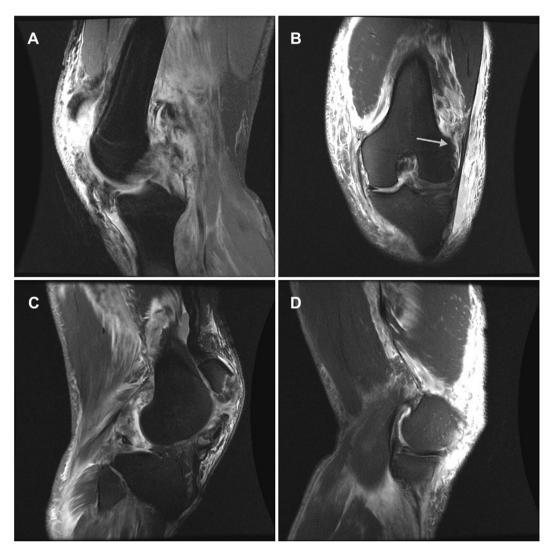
(A) Magnetic resonance imaging of the knee findings: disruption of the anterior cruciate ligament and posterior cruciate ligament; (B) tear of the lateral collateral ligament from the femoral origin site (*gray arrow*); and (C) tears of the lateral meniscus and (D) medial meniscus.
